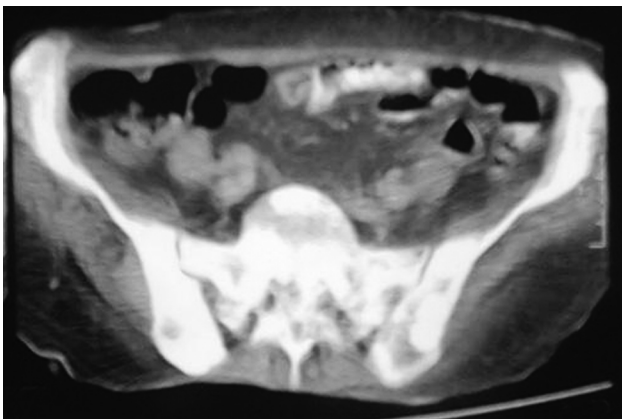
b) Pelvic CT examination revealed focal increased density at sacrum and bilateral iliac bones
